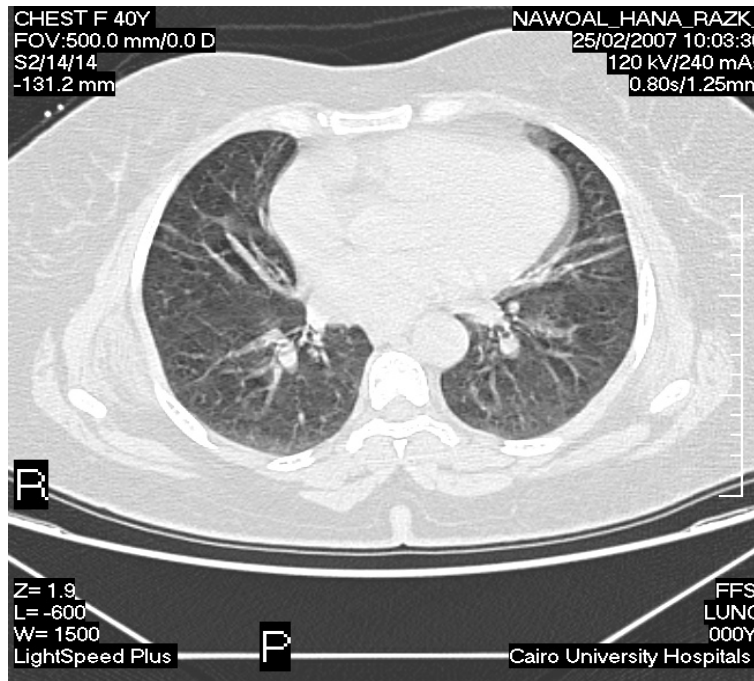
HRCT chest of case (no.28) A 51 year old female patient with HCV infection. She had no chest complaint and was a non smoker. This cut of HRCT of the chest showed bilateral areas of groundglass attenuation in the lower lung zones and the rest of the cuts showed bilateral areas of high attenuation in the upper zones, non septal lines and bilateral areas of groundglass attenuation in the middle lung zones. She took a score of 16.
